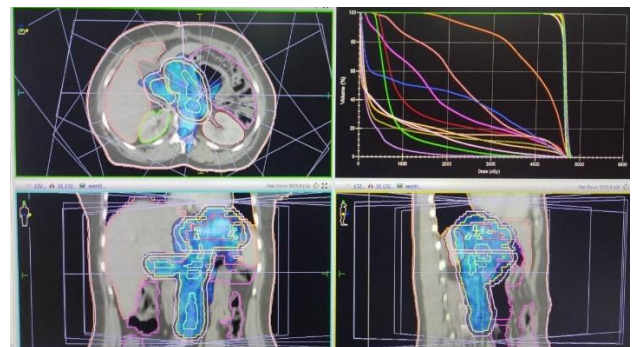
Isodose color wash on CT image (IMRT plan).
